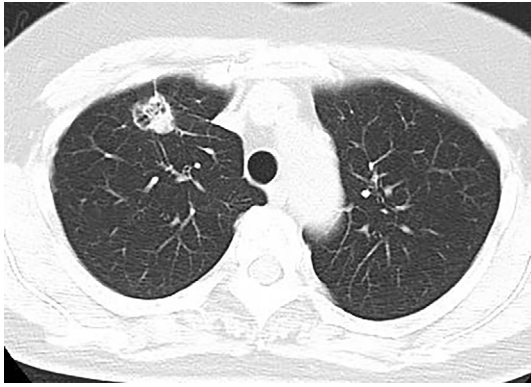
Computed tomography showing a pulmonary mass in the right upper lobe.
